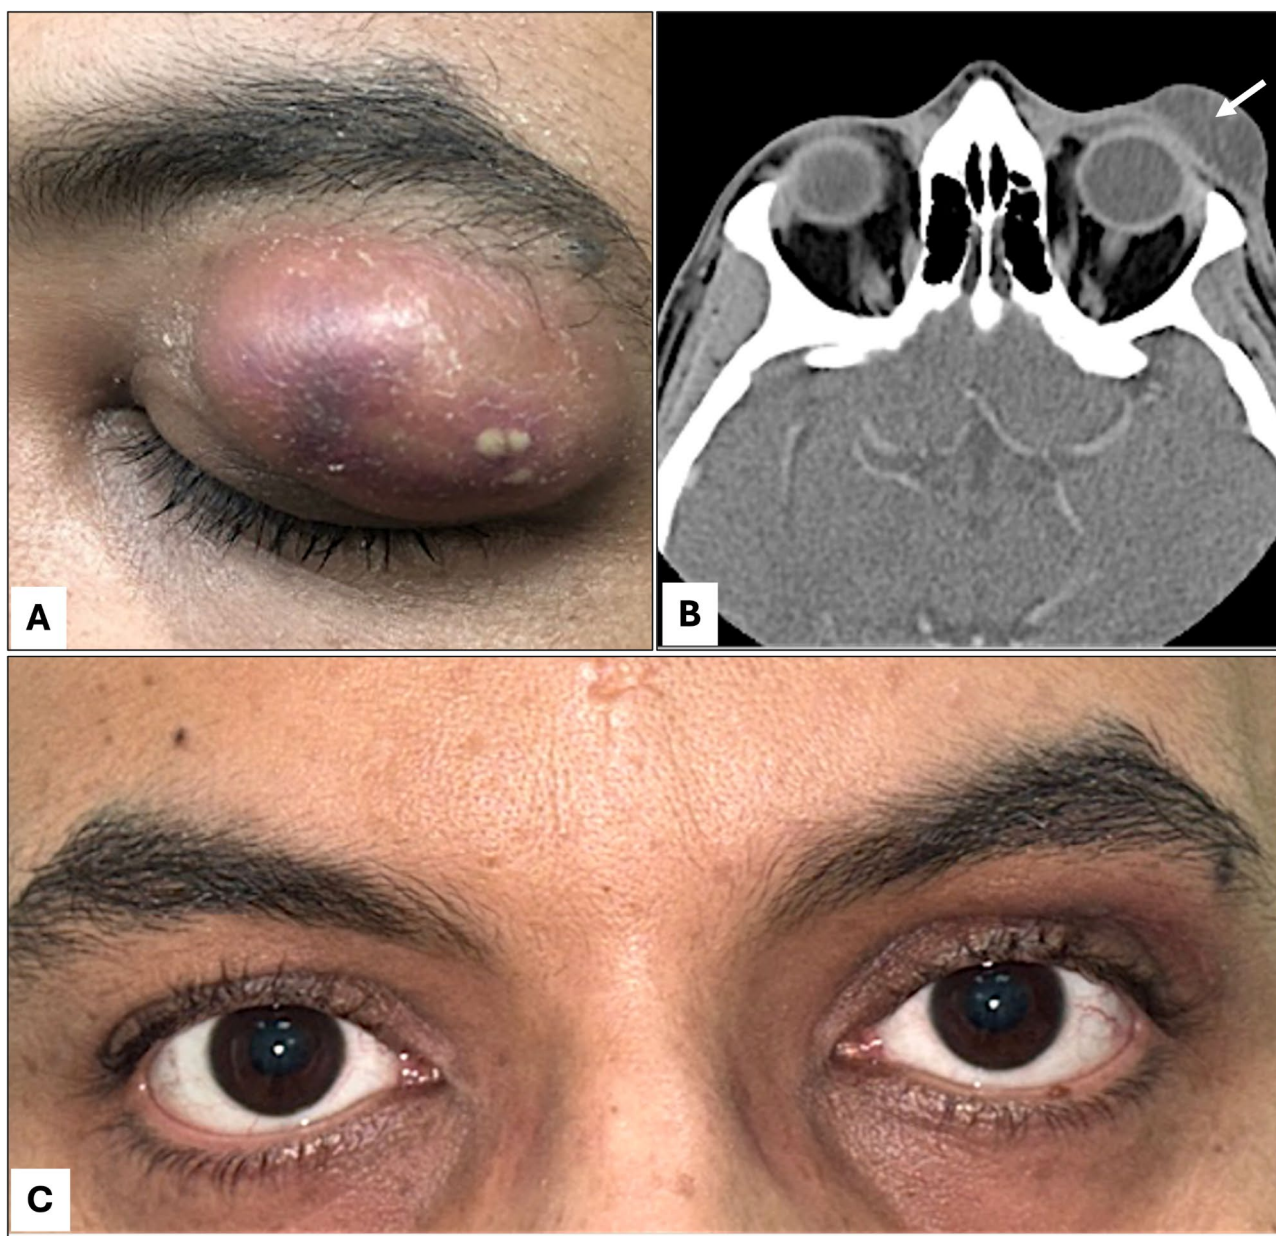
A: Preoperative appearance of swelling of the large left upper eyelid. B: Computed tomography scan outlining the eyelid as a well-circumscribed, fluid-filled lesion (white arrow) without bone or lacrimal gland involvement. C: Postoperative appearance following excision with satisfactory cosmesis
